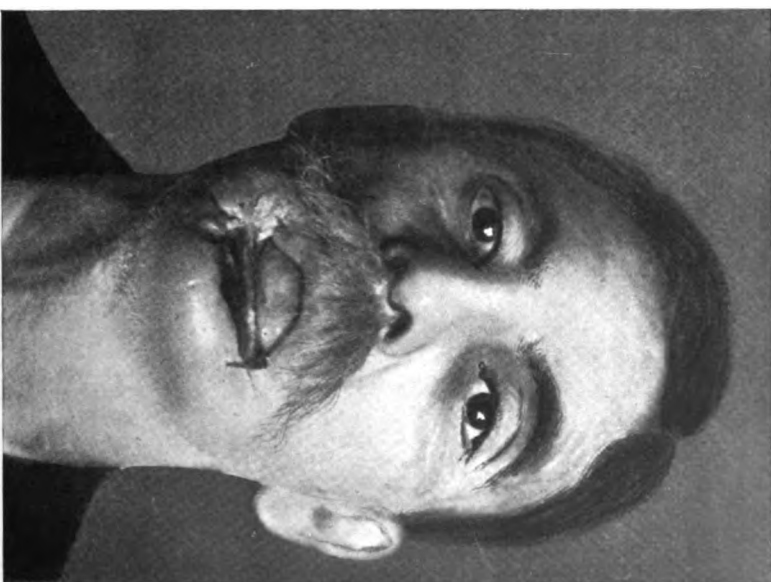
Result obtained by x-ray treatment of patient shown in Fig. 26.
